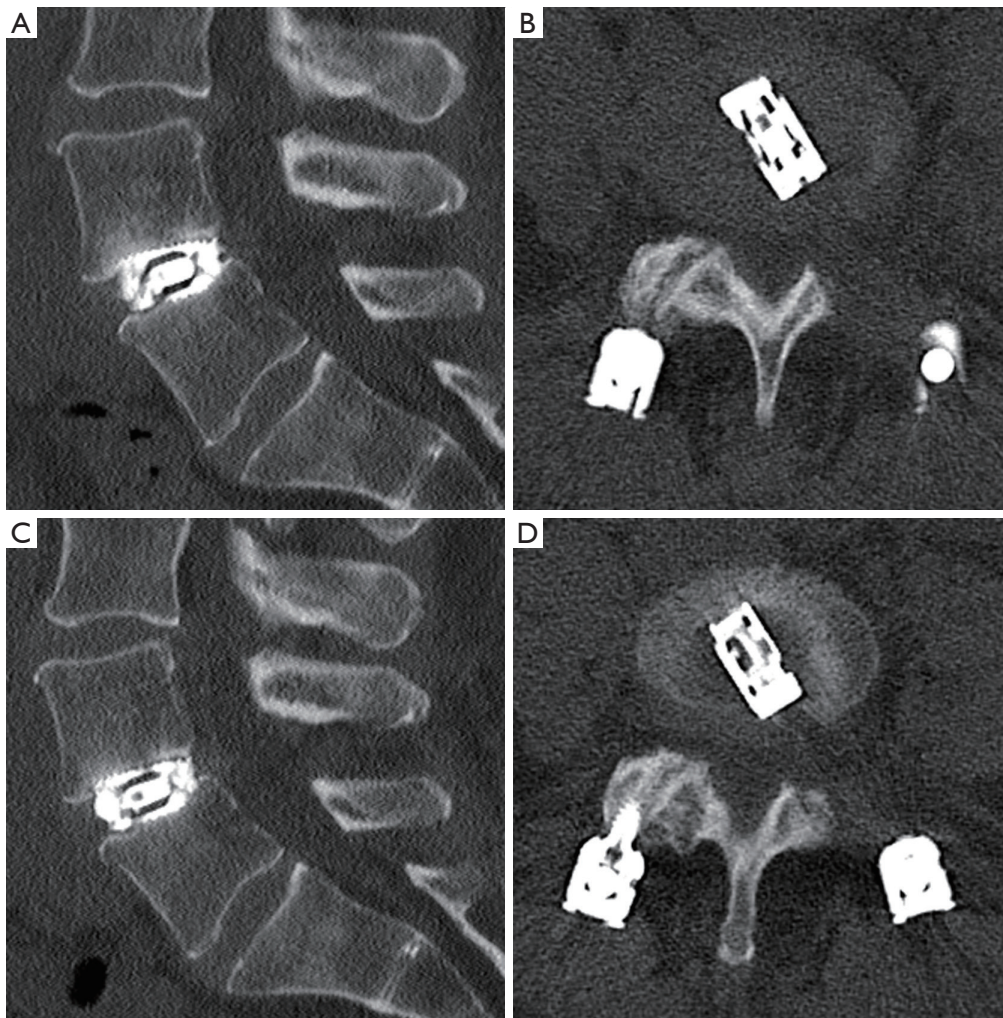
Postoperative CT scan showing cage positioning at level L4/5: (A) sagittal 6-month; (B) axial 6-month; (C) sagittal 12-month; (D) axial 12-month. CT, computed tomography.
